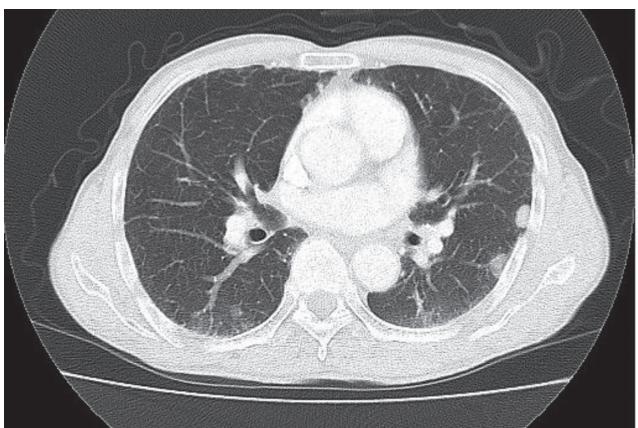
Chest CT shows metastatic lung tumors.
